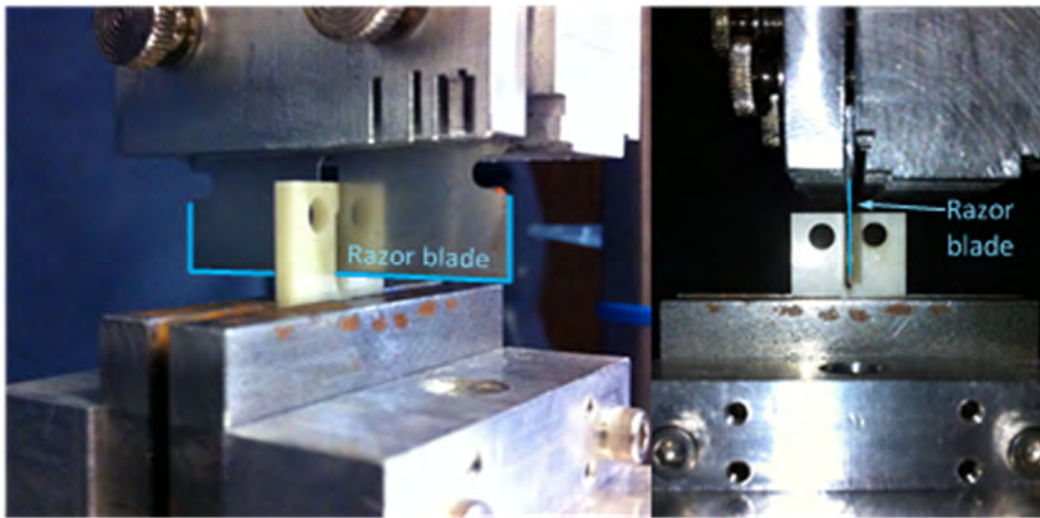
Prior to CT fracture toughness test, a pre-crack with a depth of 0.5mm was introduced at the tip of chevron notch using a razor blade (marked by the blue lines).
